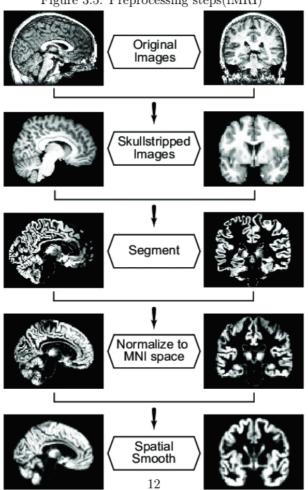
Preprocessing steps(MRI)
